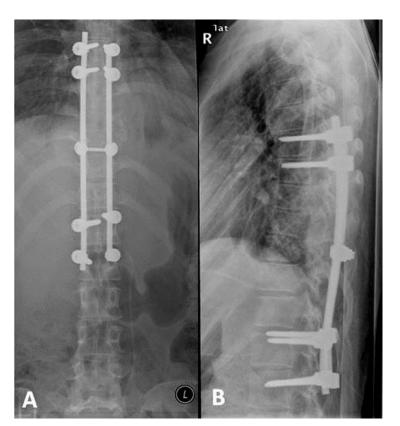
A 30 year old female with atypical spinal tuberculosis. Post-operative thoraco-lumbar spine x-ray. A-AP view (mAs 15.5, kV 77), B- Lateral view (mAs 35.7, kV 81) showing instrumented posterior spinal stabilization of the thoraco-lumbar spine.
